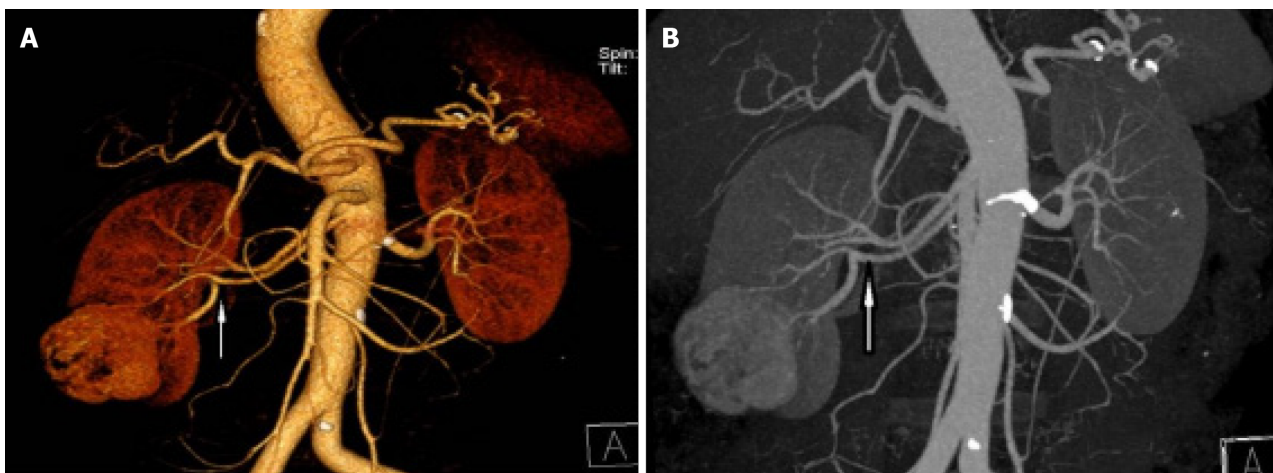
A mass showing ectopic renal artery blood supply on contrast-enhanced computed tomography. A and B: The ectopic artery flows from the abdominal aorta below the renal artery, supplying blood to the middle and lower pole part of the right kidney and the tumor.
